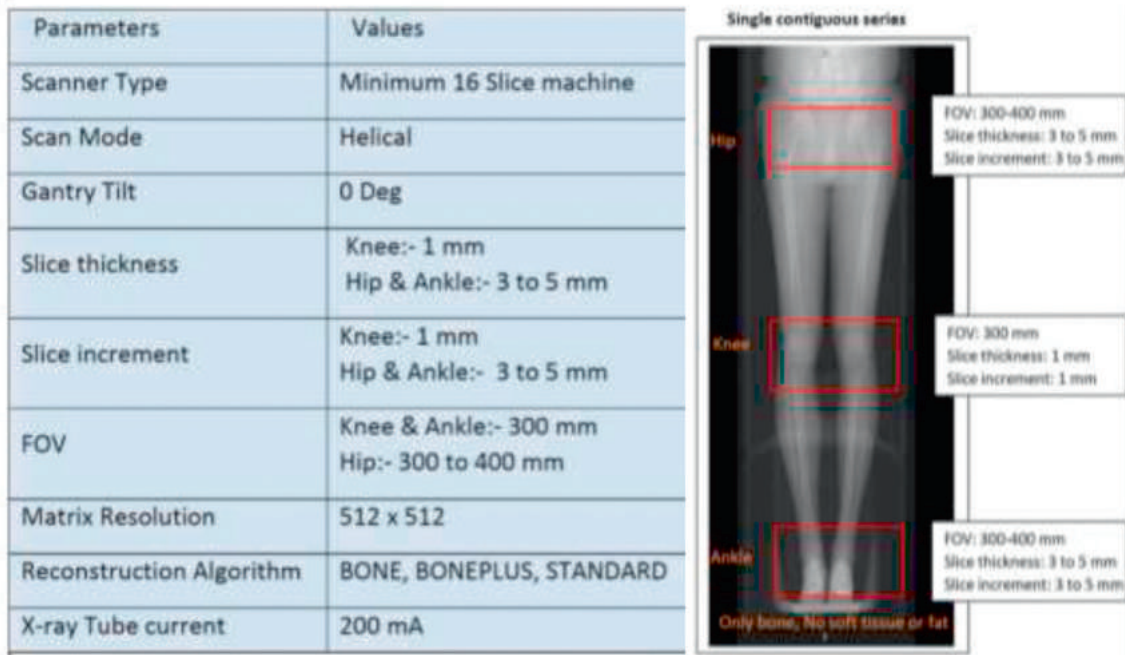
CT Scan Protocol for scan configuration.
